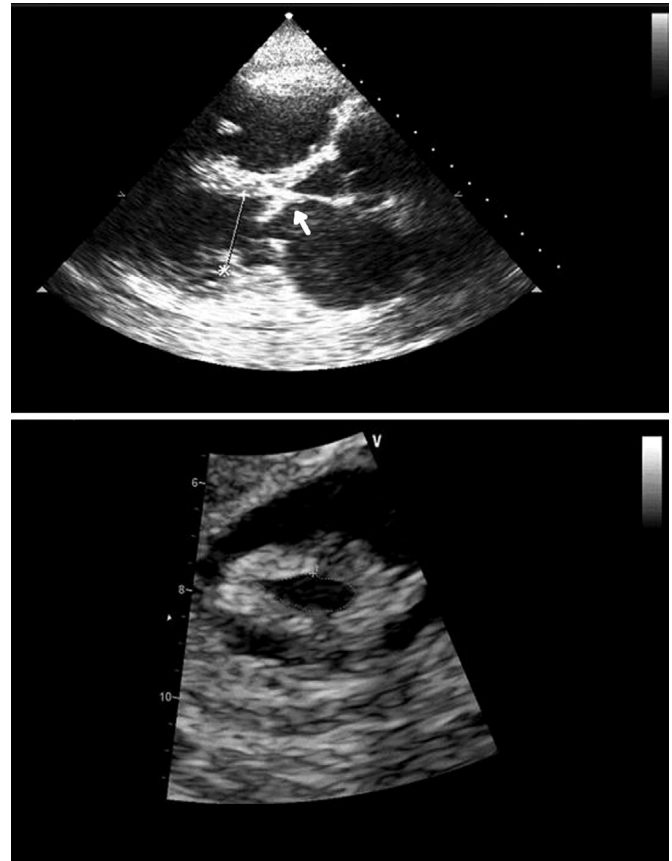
Echocardiogram. Parasternal long-axis echocardiographic view of a mitral valve of an RHD patient with valve regurgitation. Adapted from Echocardiography Department, from Heart Institute (InCor), São Paulo, Brazil.
